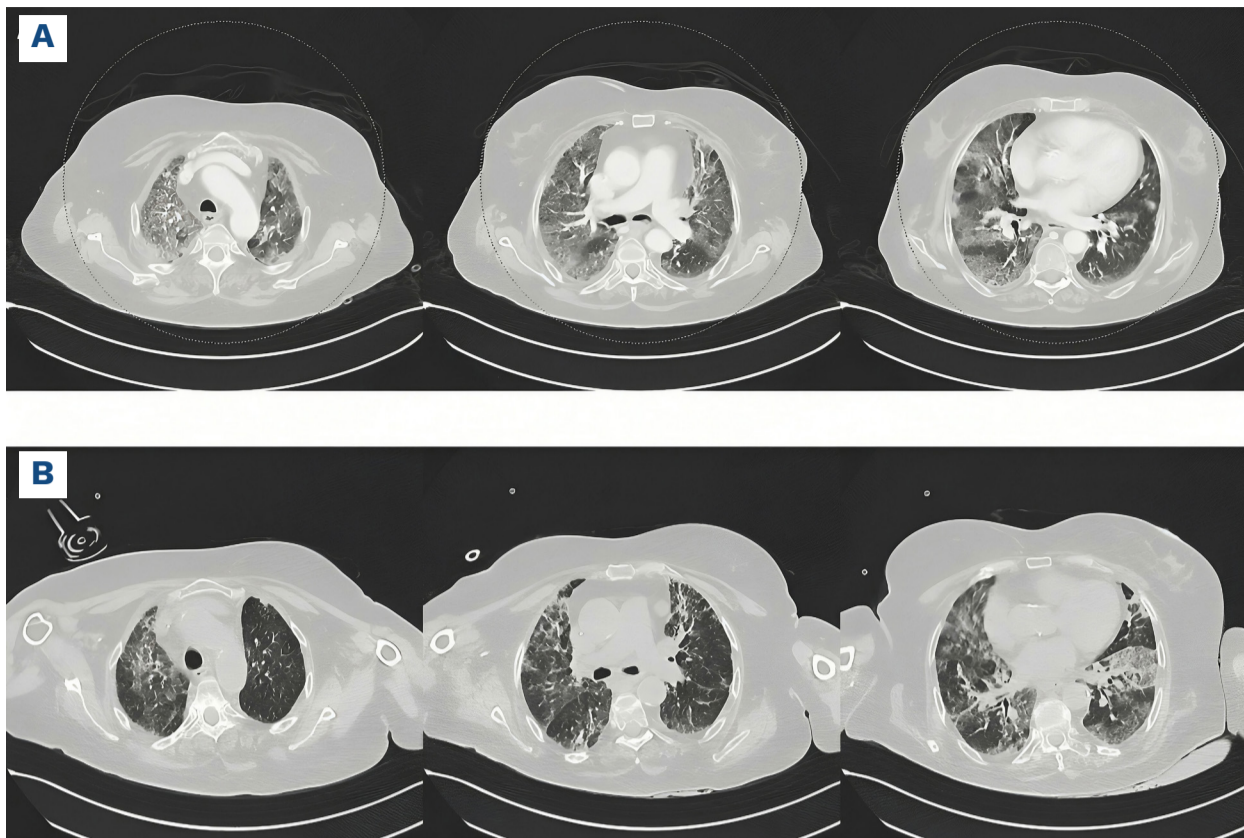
High-resolution computed tomography scans of immune effector cell-associated hemophagocytic lymphohistiocytosis-like syndrome at diagnosis and after treatment. Bronchoalveolar lavage was performed after acquisition of the first computed tomography scan. (A, B) High-resolution computed tomography scans at diagnosis of immune effector cell-associated hemophagocytic lymphohistiocytosis-like syndrome (A) and after 3 weeks of treatment with anakinra (B).
